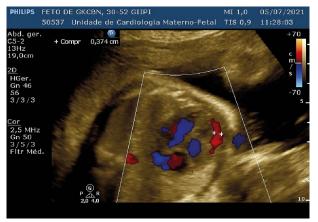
Colour flow Doppler in diastole showing flow across the atrioventricular valves and intra-pericardial flow moving in opposite direction
